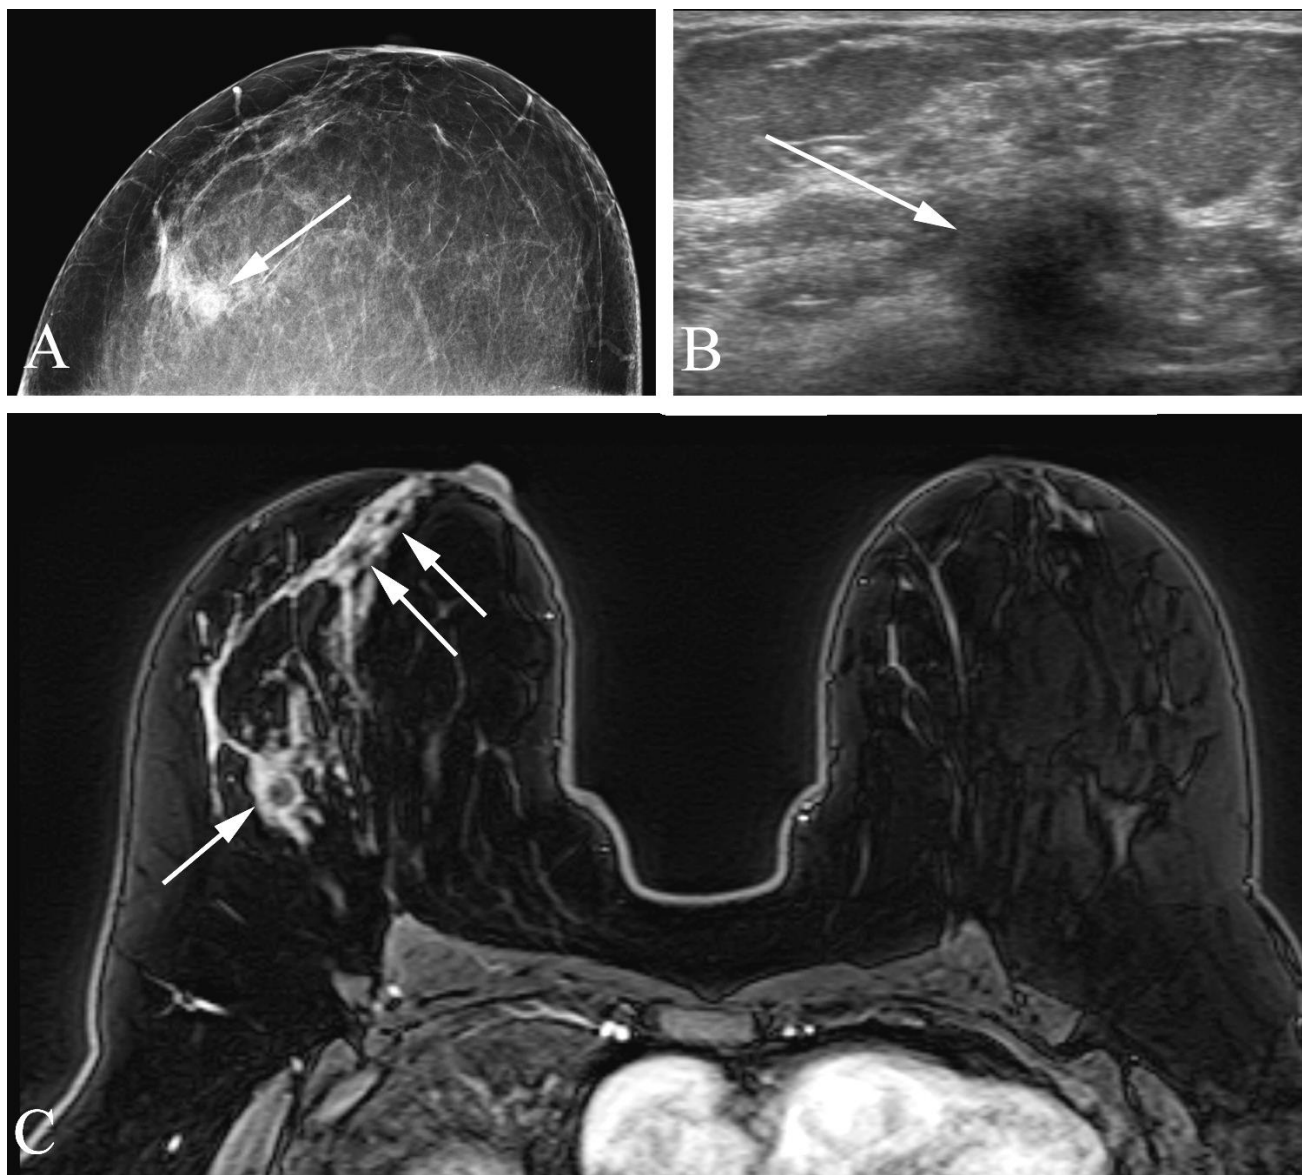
Infiltrating ductal carcinoma in a 41 year old woman with MRI demonstrating additional disease not detected at initial surgery. A. Right craniocaudal screening mammogram shows a mass in the lateral breast (arrow). B. US of the breast confirms a malignant appearing mass (arrow). C. Contrast enhanced MR examination of the breasts done following excision of an infiltrating ductal carcinoma demonstrates the operative site (arrow). Abnormal tissue extends from the biopsy site to the nipple (double arrow). Imaging directed biopsy of this region demonstrated multifocal high-grade DCIS beyond the margins of the initial surgery.
